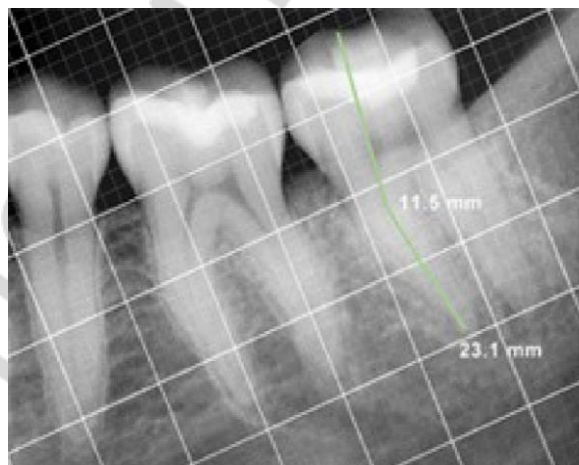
X-ray grid system
